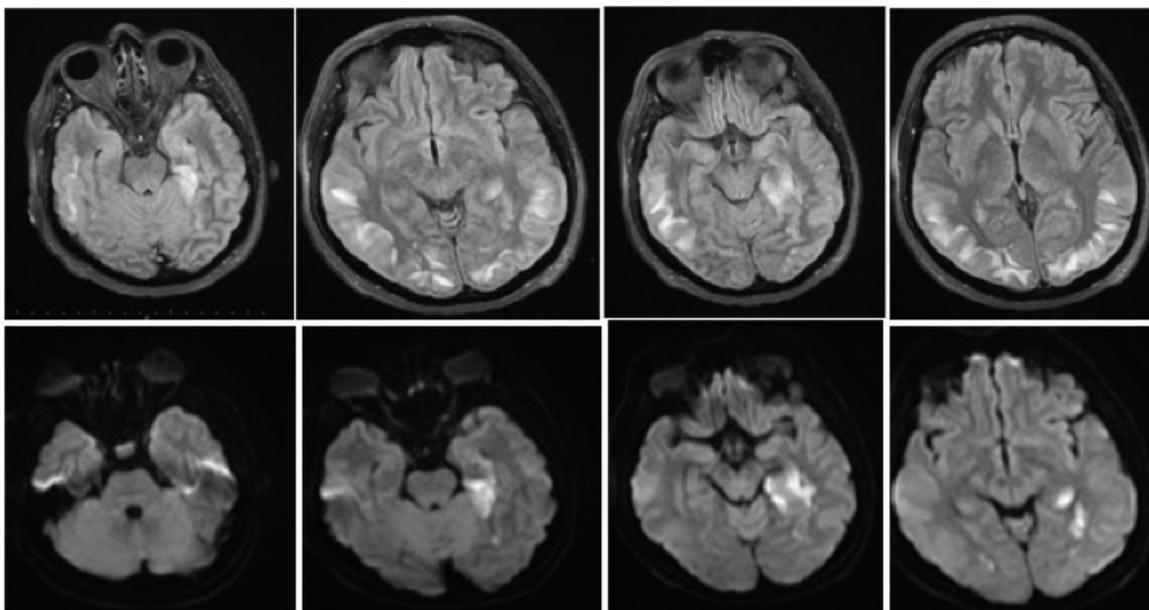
Patient's first Brain MRI Findings.
